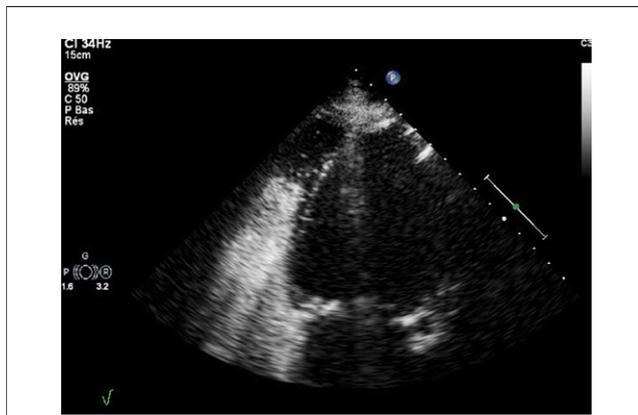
Intravenous Injection of an Echocardiographic Contrast Agent
